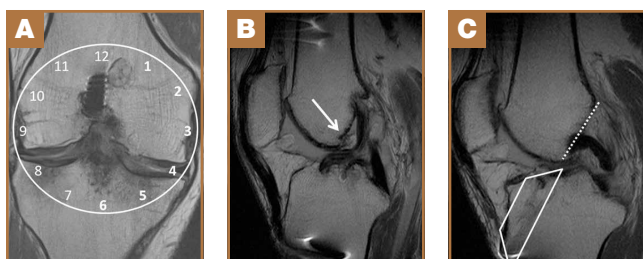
(A) Intermediate-weighted coronal magnetic resonance imaging (MRI) shows vertical (“over-the-top”) placement of femoral tunnel at 12 o’clock. This positioning results in loss of isometry of graft through full range of knee motion. Ideally, femoral tunnel is placed between 1 and 2 o’clock (left knee) or between 10 and 11 o’clock (right knee). (B) Sagittal intermediate-weighted MRI shows large osteophyte (white arrow) projecting posteriorly from inferior intercondylar roof bows and displaces the graft—compatible with graft impingement. (C) Sagittal intermediate-weighted MRI (same patient) shows tibial tunnel (white trapezoid) slightly anterior to Blumensaat line (dotted line). Correct tibial tunnel placement, slightly posterior to intersection of Blumensaat line and tibial cortex, avoids graft impingement.
